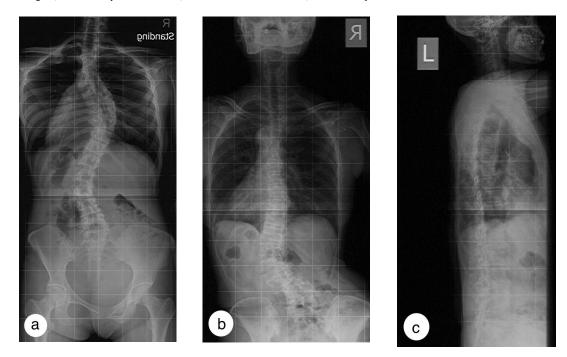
(a) An adult with idiopathic scoliosis. She is in her thirties, and rigid brace if prescribed can be corrective in three dimensional. (b) An adult with degenerative lumbar scoliosis. Rotary olisthesis is evident at L3/4 level, with coronal shift. (c) The lateral full spine x-ray of the same patient as (b). Prescription of a rigid brace in this patient should be a sagittal realignment brace.
